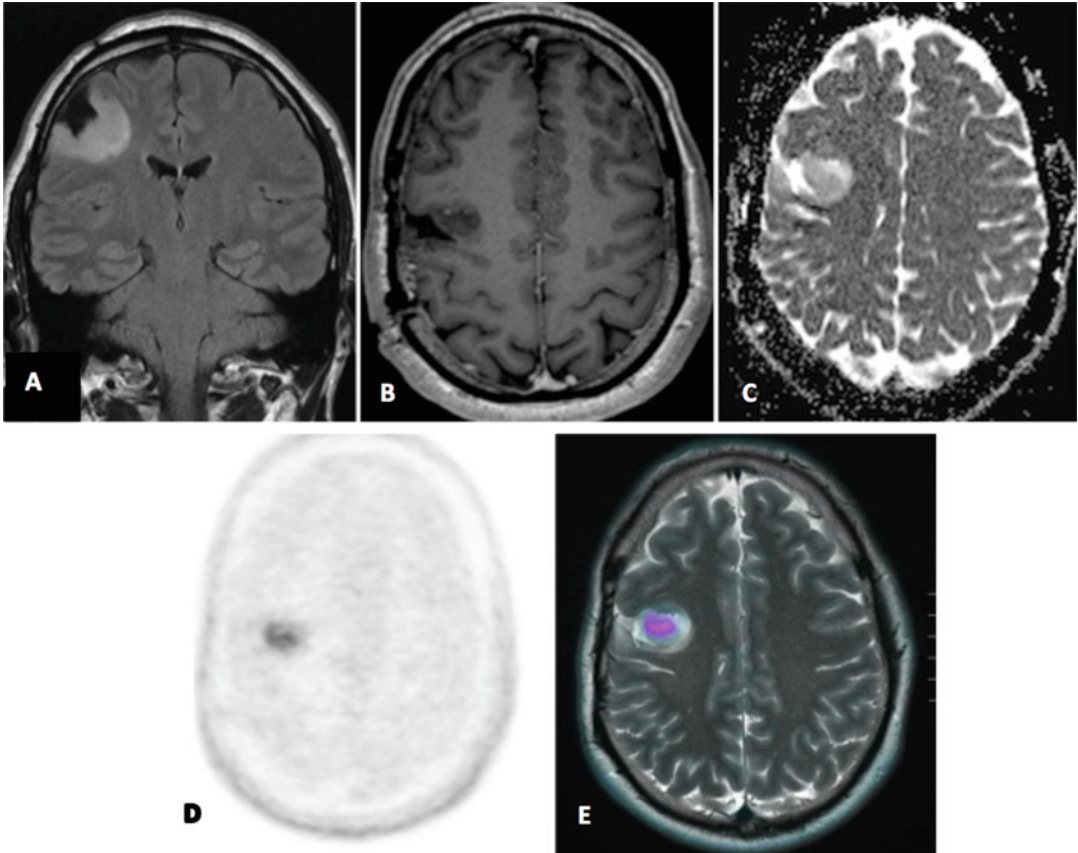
Coronal T2W FLAIR (a), axial postcontrast T1WI (b), axial ADC map (c), axial ^{18}F DOPA PET (d), and axial fused ^{18}F DOPA PET/MR (e) demonstrating a nonenhancing area in the right frontal lobe in a patient
